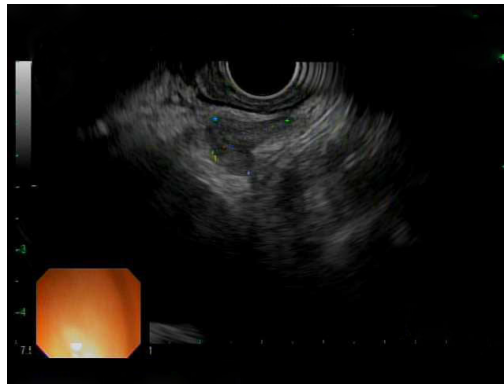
Endoscopic ultrasound image of subcarinal lymph node.
